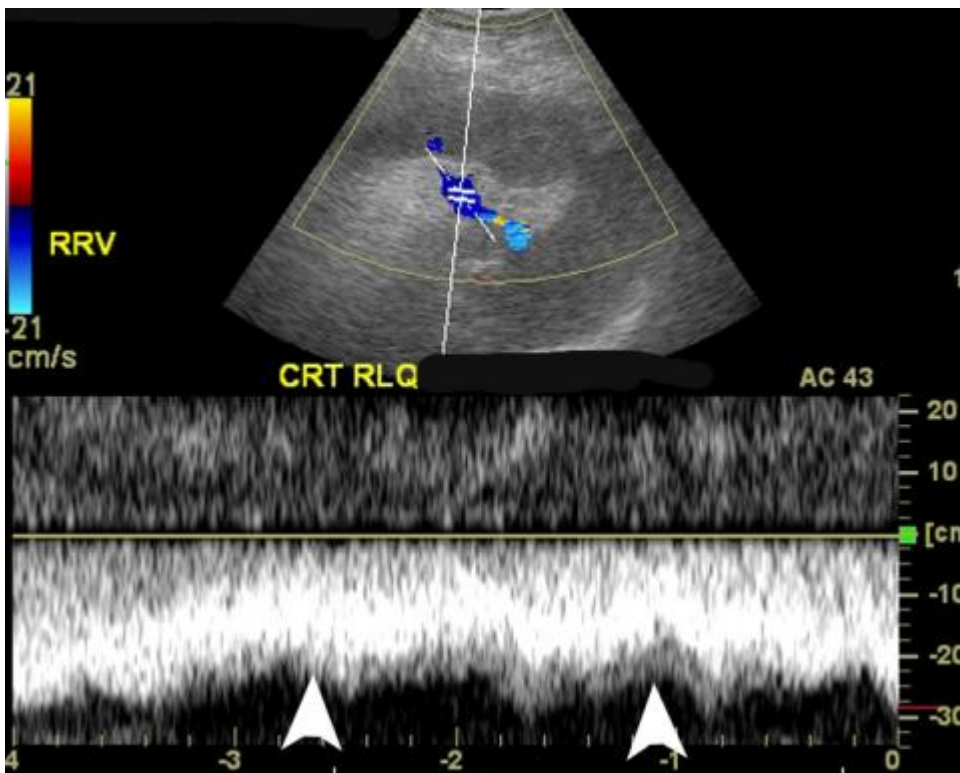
Normal renal vein shown on spectral Doppler ultrasound. The normal renal venous waveform (arrowheads) is continuous and monophasic.
